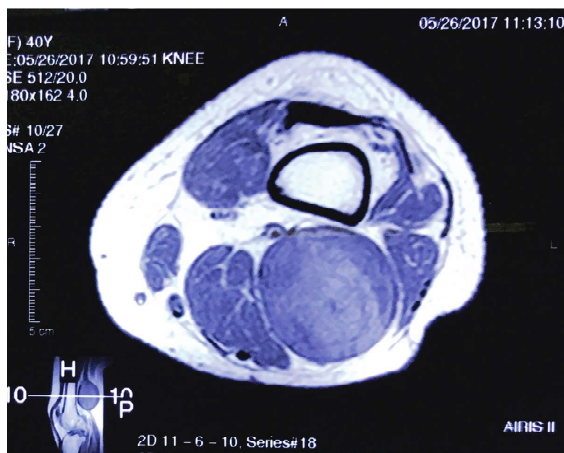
T1 weighted MRI images in transactional view of left popliteal fossa showing heterogeneously hypointense lesion is T1W.
